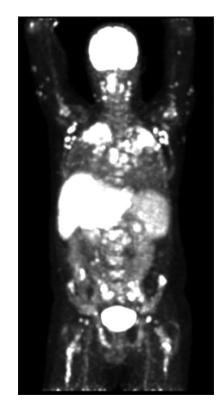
Positron emission tomography–computed tomography demonstrating disseminated metabolic activity in lungs, liver, spleen, lymph nodes and bone marrow
